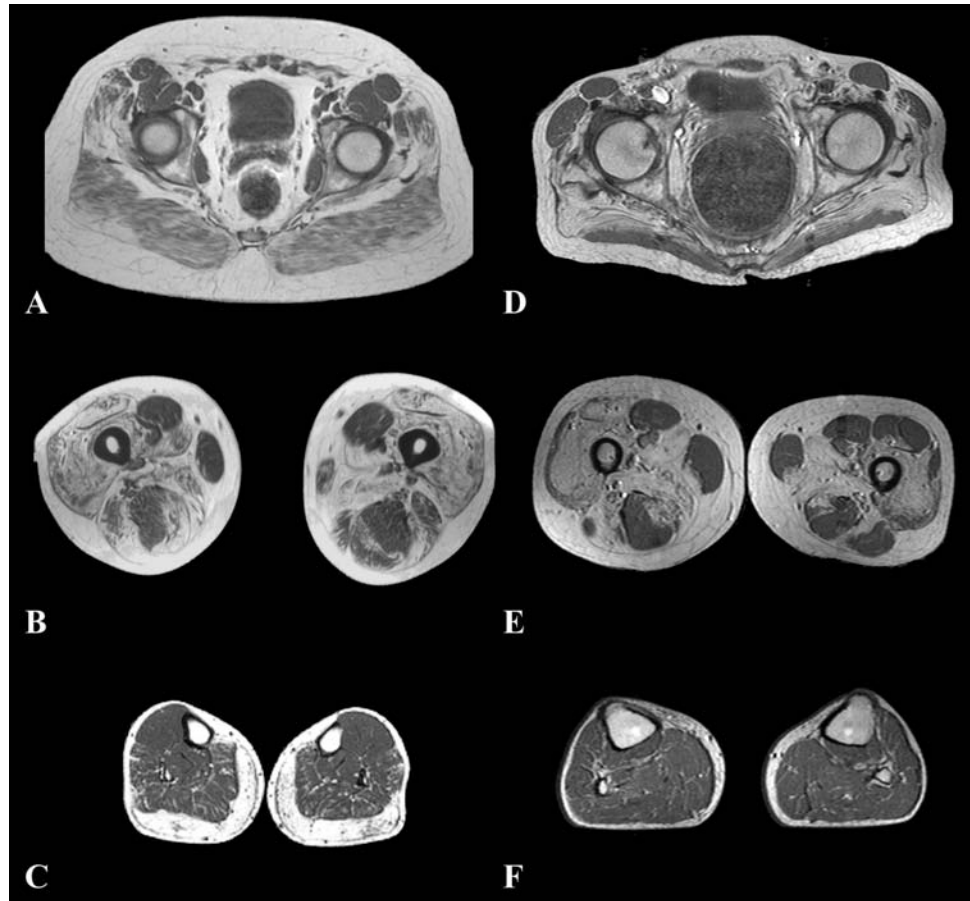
Muscle MRI in dysferlinopathy in three patients with a mild (A, B, C), moderate (D, E, F) and severe (G, H, I) clinical phenotype. At the pelvic level, there are mild to moderate signal changes in the gluteus minimus muscle in all patients. At the thigh level, there is predominant anterior compartment involvement in some patients (B), whereas the posterior compartment muscle exceeds the anterior compartment muscle involvement in others (E, H). A similar heterogeneity is observed in the lower legs. Some patients show a relative selective involvement of the gastrocnemius and soleus muscle (C), whereas others show marked hyperintense signal abnormalities in the anterior lower leg compartment, too (F). In the patient with a severe clinical phenotype, all muscles in the lower leg show a similar pattern of involvement (I)
